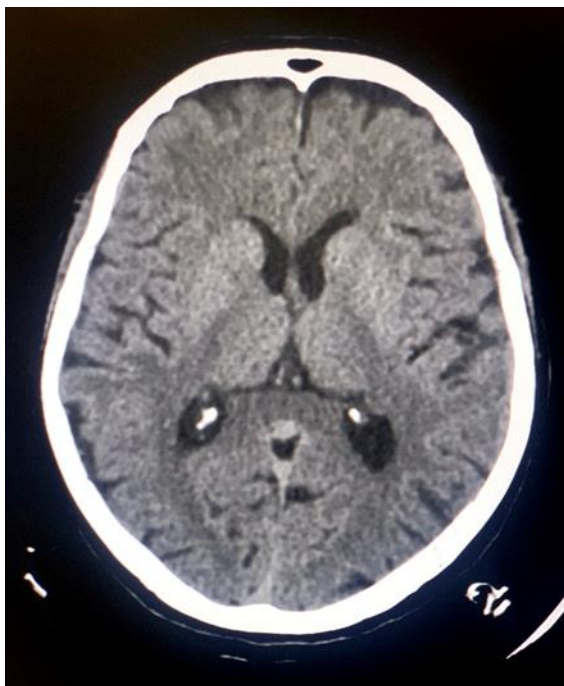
CT head Image with Choroid Plexus calcification in the posterior horn of lateral ventricle
